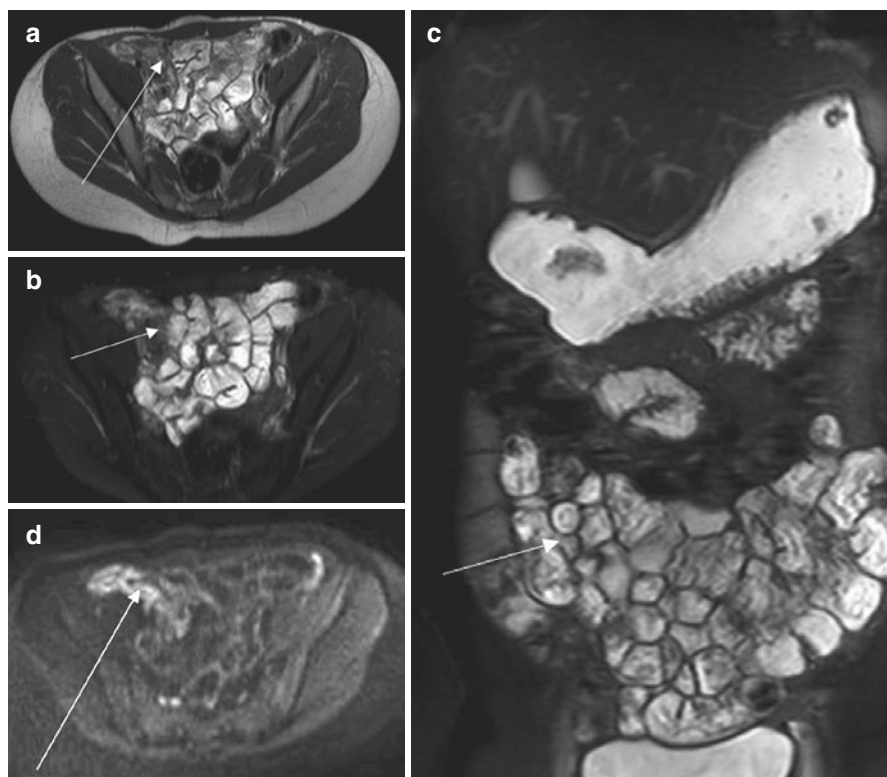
Utility of diffusion-weighted imaging (DWI) in diagnosing terminal ileal Crohn's disease—The terminal ileum is under distended on the (a) axial T2 HASTE sequence, (b) axial HASTE fat saturated sequence and (c) coronal HASTE fat saturated sequence and so indeterminate for Crohn's disease involvement. (d) Axial DWI-weighted image (B value = 600 s/mm^2) shows abnormal increased linear high signal in the bowel wall suggestive of ileitis
